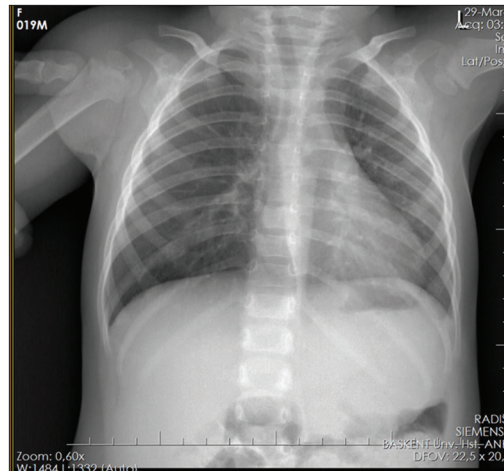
The chest radiograph that was taken during admission
